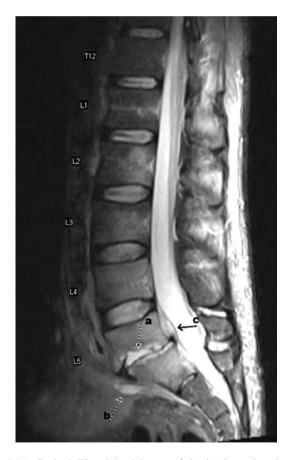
Sagittal T2-weighted image of the lumbar spine demonstrates fluid in the L5–S1 disc space and destruction of the inferior end plate of L5 consistent with discitis and osteomyelitis (a). There is a small, ovoid fluid collection in the anterior paraspinal soft tissues (b). There is heterogeneous soft tissue in the epidural space with elevation of the posterior longitudinal ligament (c)
